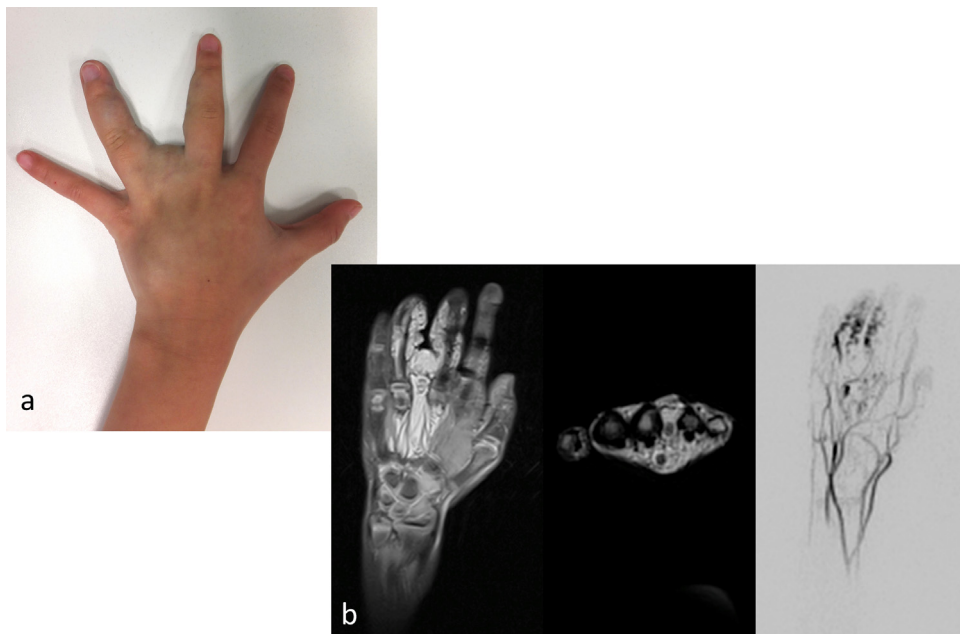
a–b: Clinical impression of the VM and MRI with TWIST angiography. MRI was performed for further characterization of flow dynamics and potential arterial feeder. Good MRI delineation of the extension of the malformation in the hand (Fig. 3a). Limited diagnostic information on TWIST angiography (Fig. 3b).
